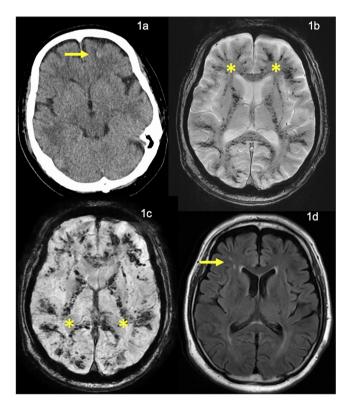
A, Brain computed tomography showing subcortical hemorrhage (yellow arrow). B, T2*-weighted image and (C) Susceptibility-weighted image showing diffuse, symmetrical microbleeds in subcortical white matter (U-fibers) (*). D, Minor lacuna in frontal white matter on T2-FLAIR image (yellow allow)
